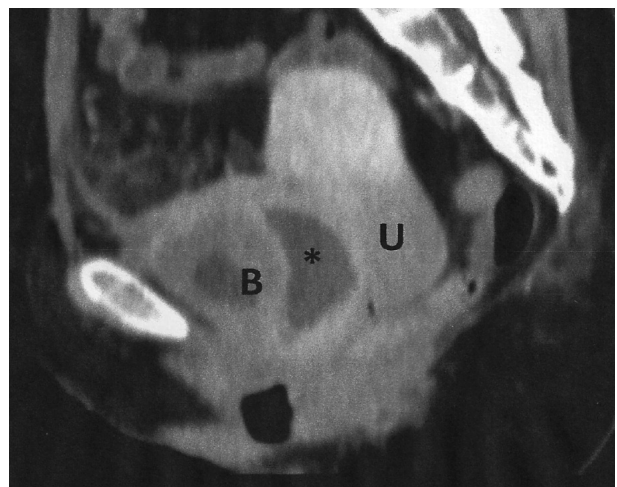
The CT scan revealed necrotic mass (*) between urinary bladder (B) and uterine cervix (U), surrounded by fat stranding. The bladder wall is markedly thickened.
